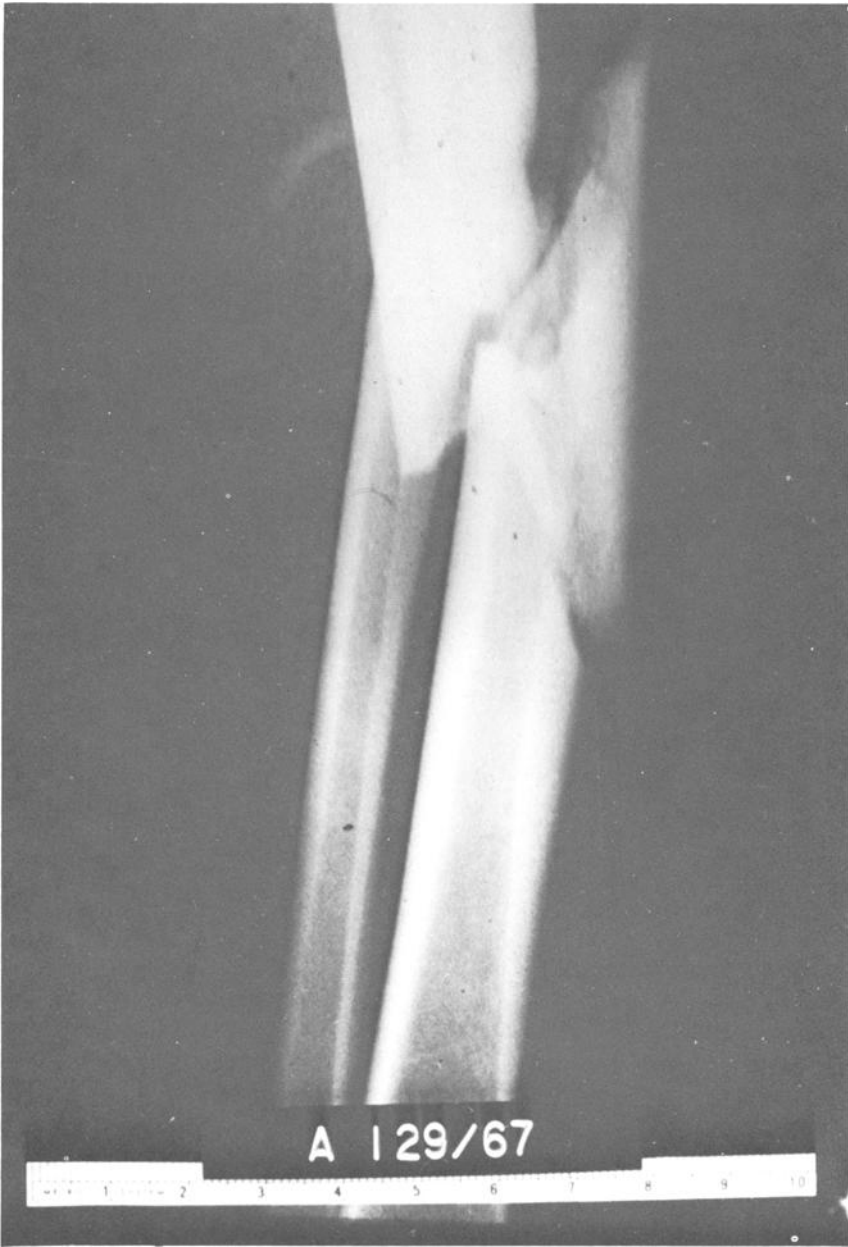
Roentgenogram demonstrating fractures of tibia and fibula, occurring during motorcycle accident.
